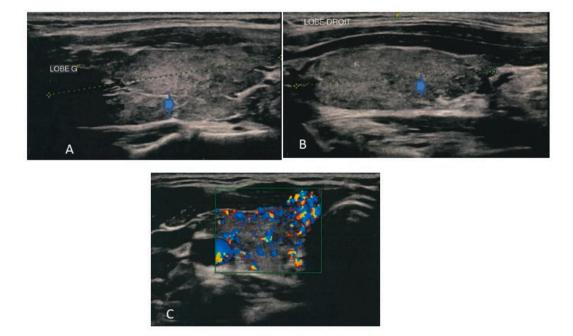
Case 1: Thyroid gland ultrasound on longitudinal scan (A: left lobe, B: right lobe) showing heterogenous parenchymal echostructure with steaky lines (blue arrow); C: right lobe thyroid gland color doppler ultrasound on transversal section showing diffuse parenchymal hyperhemia.
